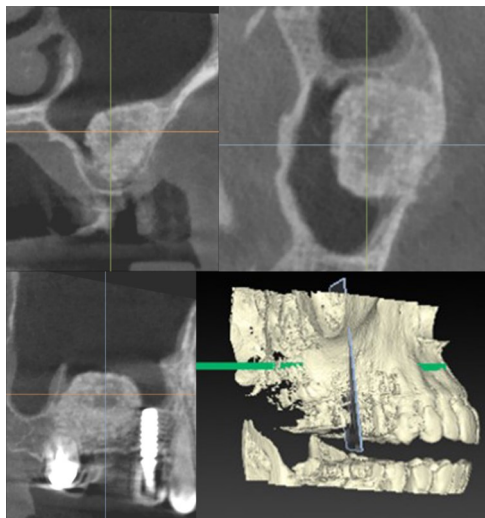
CT scan after 5 months of biomaterial deposited in the maxillary sinus lift.
